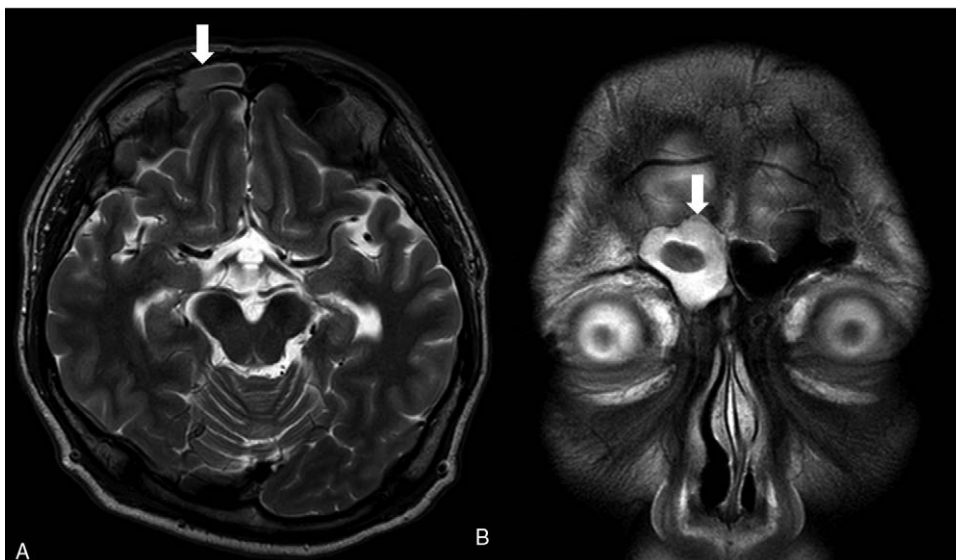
Magnetic resonance imaging with contrast of the brain showing right frontal sinus hematoma (White arrow)(A: a T2-weighted image, axial section, B: a T2-weighted image, coronal section).
